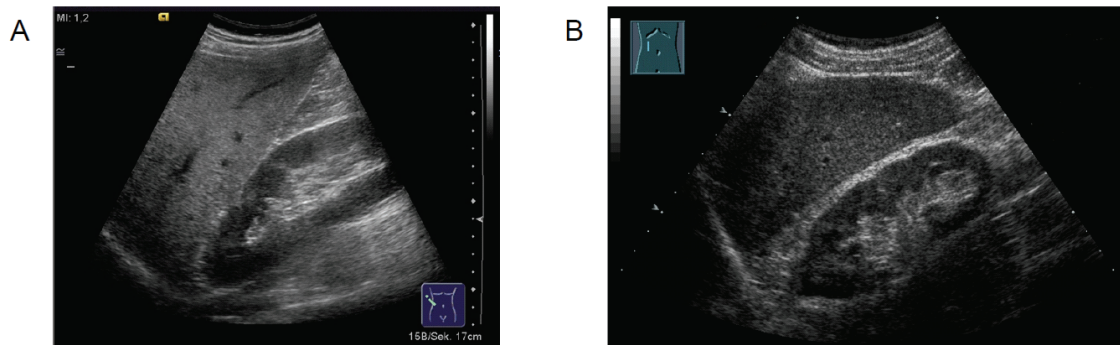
Ultrasound images of normal and steatotic livers. Ultrasound examination of liver parenchyma in longitudinal direction in the right midclavicular line using a 3-5 MHz transducer. A: steatosis hepatitis with marked increase in hepatic echogenicity compared with the normal renal cortex. B: normal liver parenchyma with homogeneous echotexture compared with normal renal cortex.
